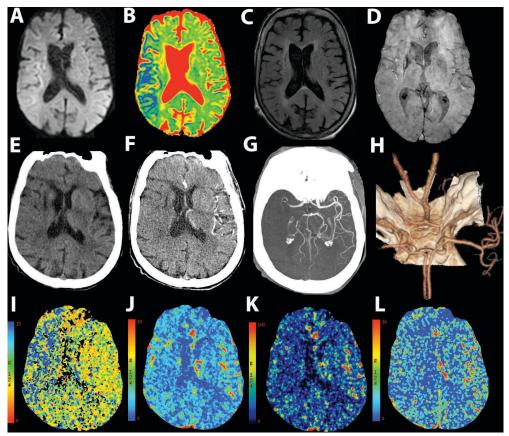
Case #2. Neuroimaging at admission. A-D. Magnetic-resonance imaging (MRI): A. Diffusion weighted imaging (DWI). B. The apparent diffusion coefficient (ADC) map. C. Fluid-attenuated inversion recovery (FLAIR). D. Susceptibility-weighted angiography (SWAN). E-L. Computed tomography (CT) scans: E. Non-contrast CT. F. CT-angiography source images (CTASI). G. Maximal intensity projection (CT-angiography). H. Volume rendering (CT-angiography). I-L. CT-perfusion study: I. The mean transit time (MTT) map. J. The cerebral blood volume (CBV) map. K. The cerebral blood flow (CBF) map. L. The permeability–surface area product (PS) maps.
